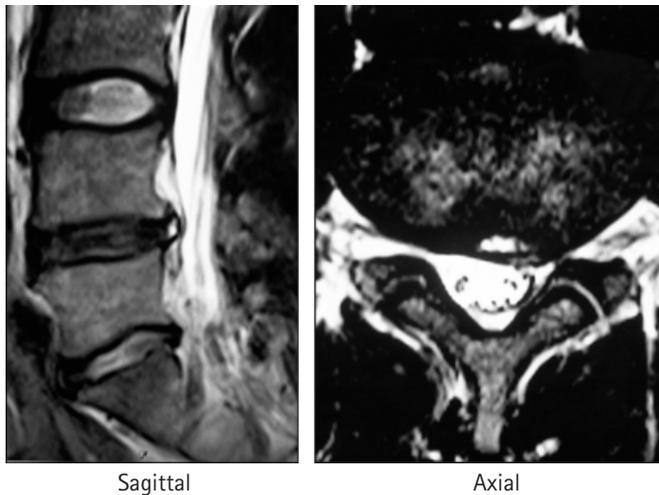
Sagittal and axial T2-weighted magnetic resonance images showing a high-intensity zone at the posterior annulus. The patient is a professional baseball player who experienced severe low back pain when playing. His pain was successfully treated by intradiscal injection.
